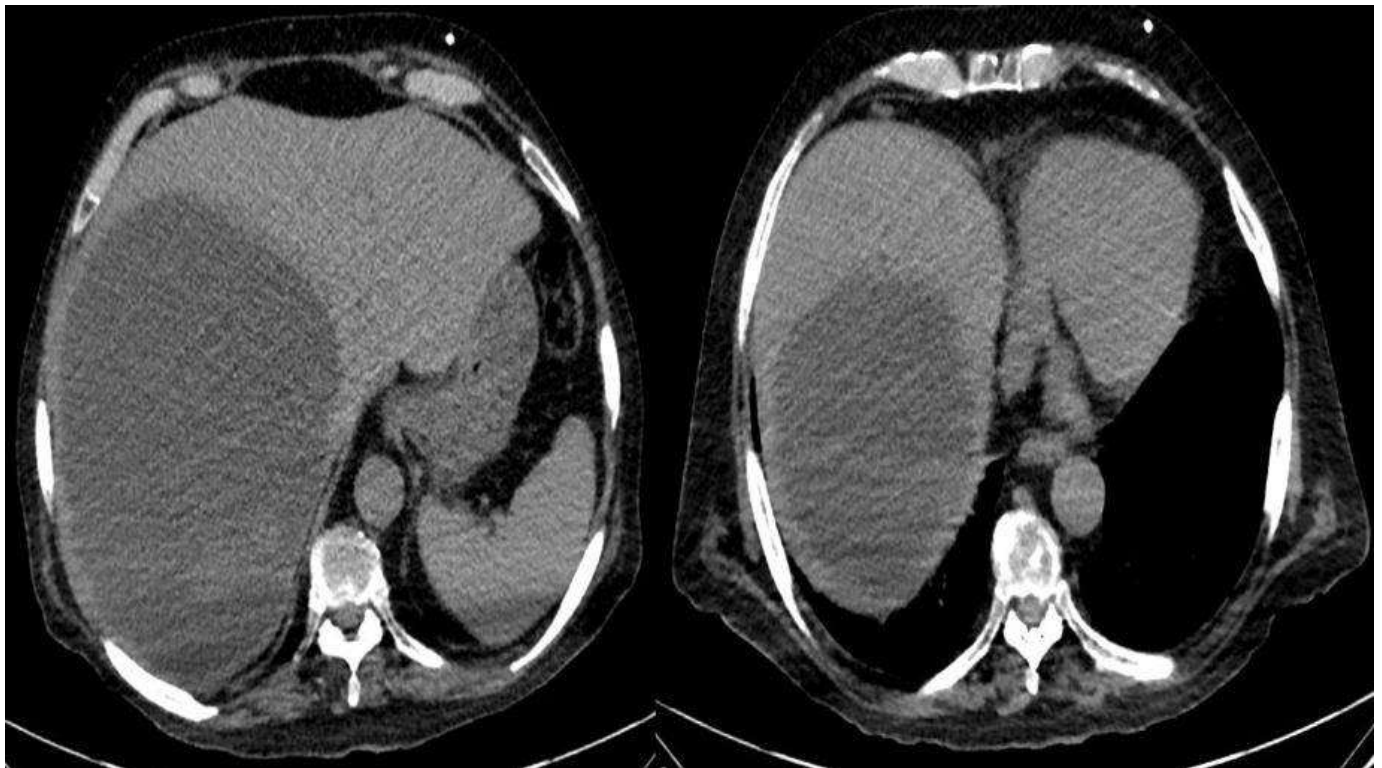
130 × 125 mm mass in the liver's right lobe on abdominal CT.
